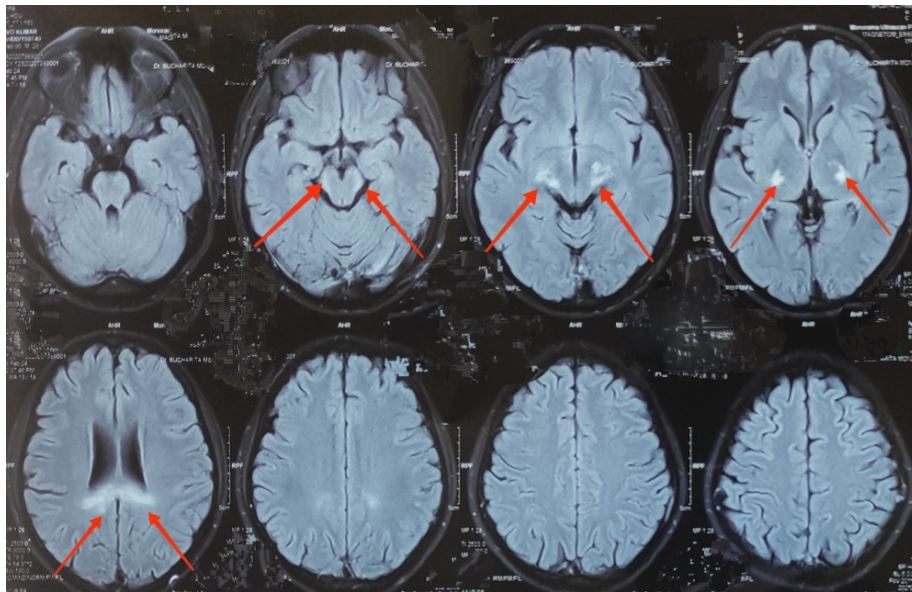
MRI of the brain, FLAIR images showing symmetric hyperintensities in the white matter tracts of brain (red arrow).
